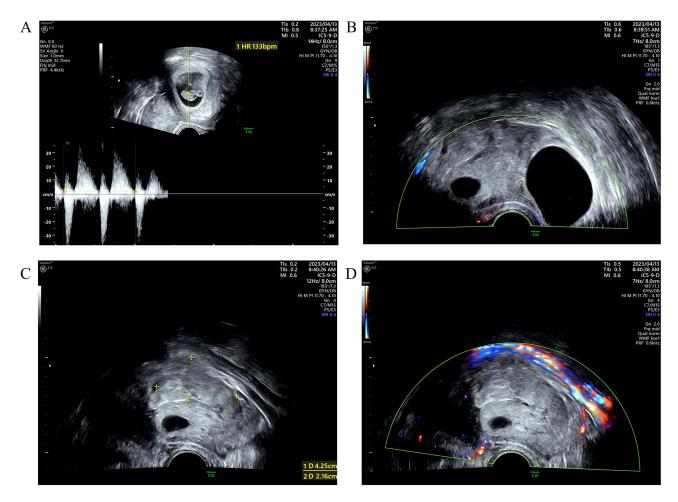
The ultrasound examination displayed suspicious ovarian torsion:(A) a live fetus in the uterine cavity; (B) an 8.3×5.2cm right ovary, and 4.0×3.3cm liquid-dark and 2.0×1.8cm liquid-dark areas in the right ovary; (C) a 4.3×3.6 cm enhanced echogenic mass above the right ovary with unclear borders and striated structures; (D) a few punctate blood flow signals could be detected in the peripheral cortex of the right ovary.
